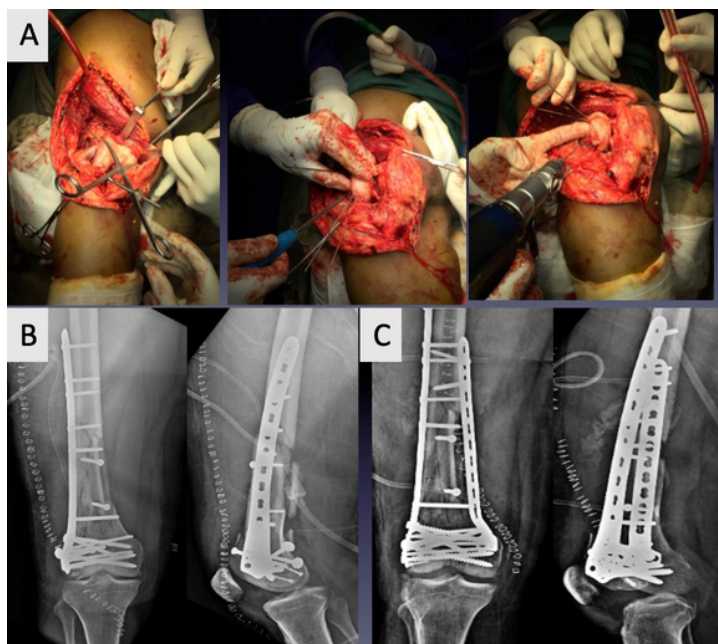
Intraoperative images of ORIF(A), Immediate Postoperative Radiographs(B), Medial plate augmentation done 1 month later(C)
